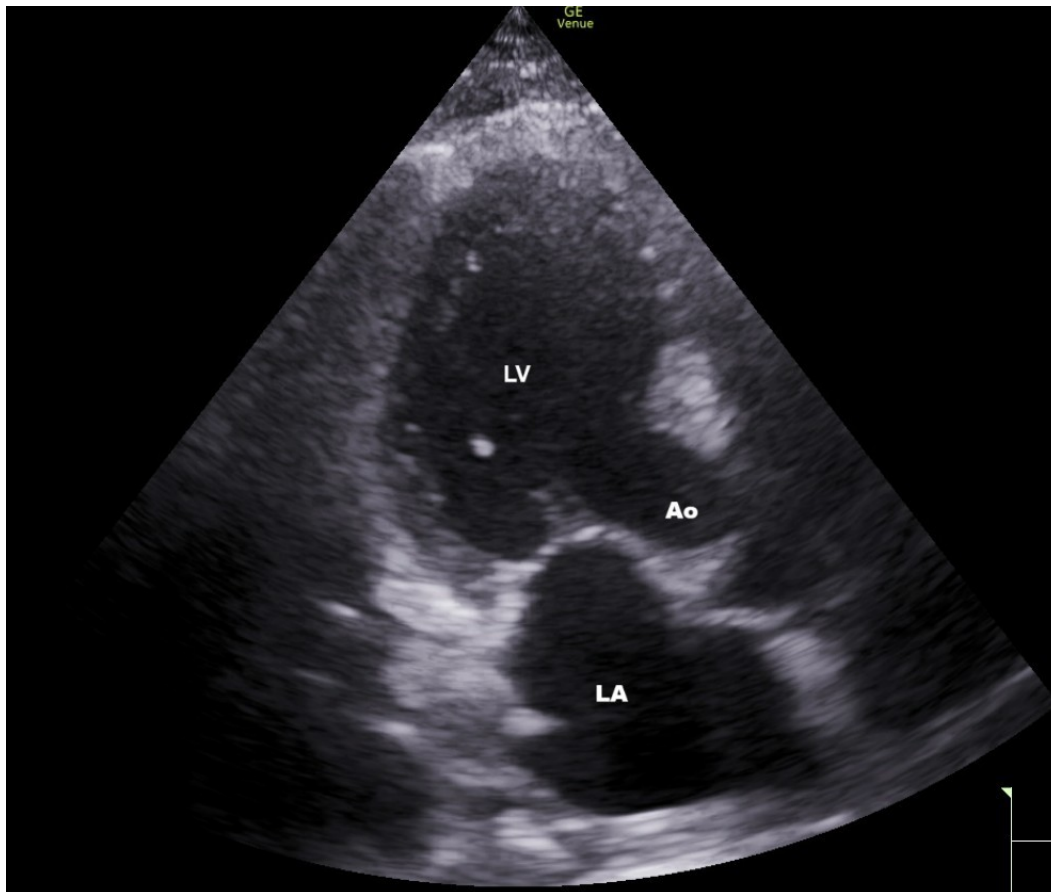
Apical Three Chamber View, LA=Left Atrium, Ao=Aorta, LV=Left Ventricle[46]
